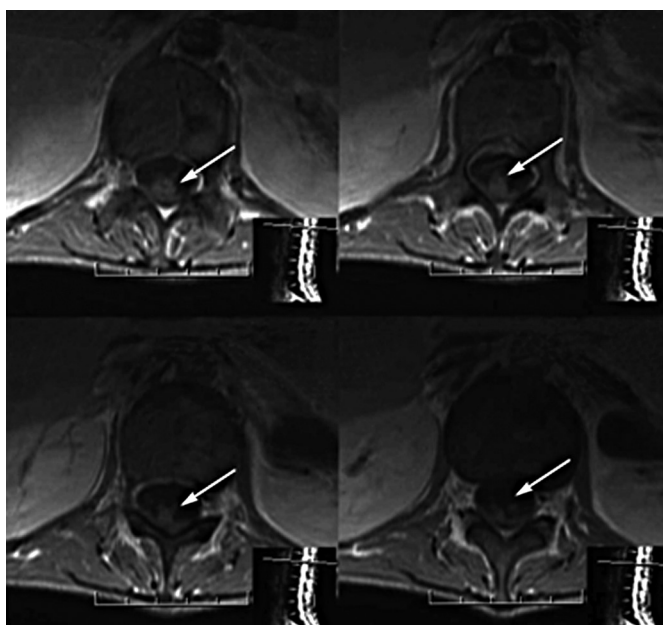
Magnetic resonance imaging of the dorsolumbar spine showing the enlargement of the conus medullaris (arrows).
